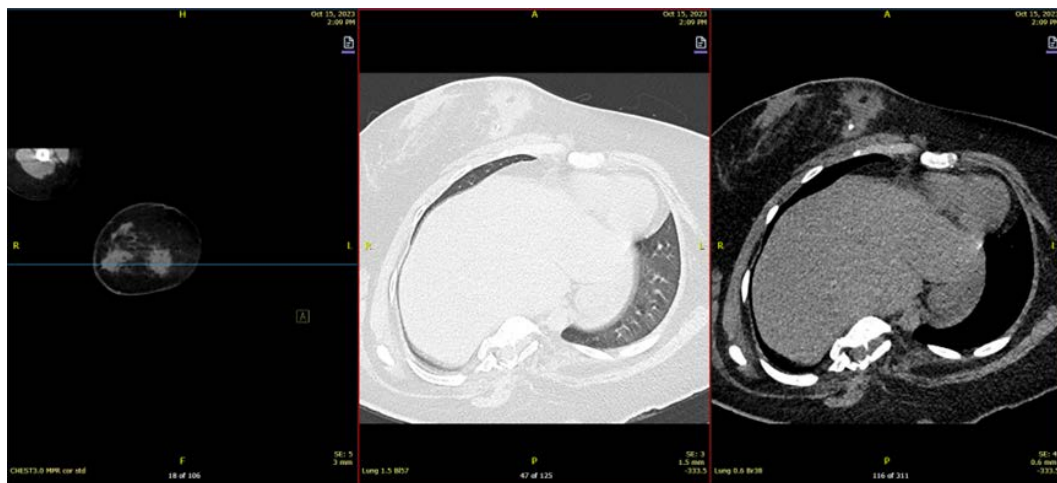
Non-contrast computed tomography demonstrating complications along the distal ventriculoperitoneal (VP) shunt tract. (A) Coronal soft-tissue window showing surrounding soft tissue thickening and fluid collection along the right-sided VP shunt tract. (B) Coronal window with adjusted contrast demonstrating hyperdense fluid collection extending from the level of the third rib to the seventh costochondral junction. (C) Axial image confirming focal fluid collection with surrounding fat stranding along the VP shunt tract in the right chest wall extending into the medial aspect of the right breast.
